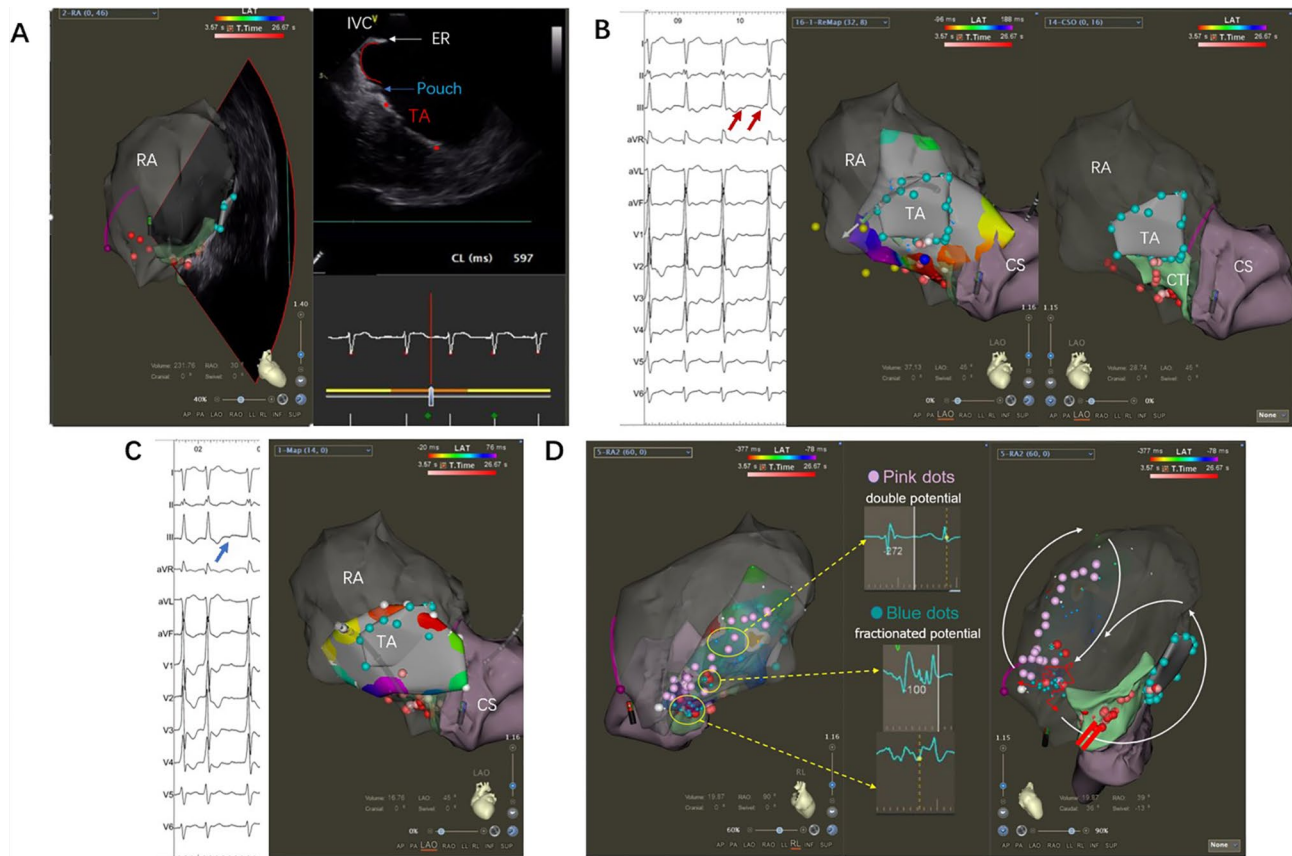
Examples of both CTI- and non-CTI related types of AFL. (A): 3D reconstruction of the RA via ICE; (B): Activation mapping of a typical counter-clockwise AFL; note that red arrows represent a negative F wave in the inferior leads; (C): After ablation of the CTI, remapping indicated that the CL of the TA was insufficient; note that blue arrows represent a positive F wave; (D): Special electrograms recorded around the inferior lateral right atrium with potential reentry of figure-of-eight in this case. AFL, atrial flutter; CL, cycle length; CS, coronary sinus; CTI, cavotricuspid isthmus; ER, Eustachian ridge; ICE, intracardiac echocardiography; IVC, inferior vena cava; RA, right atrium; TA, tricuspid annulus
